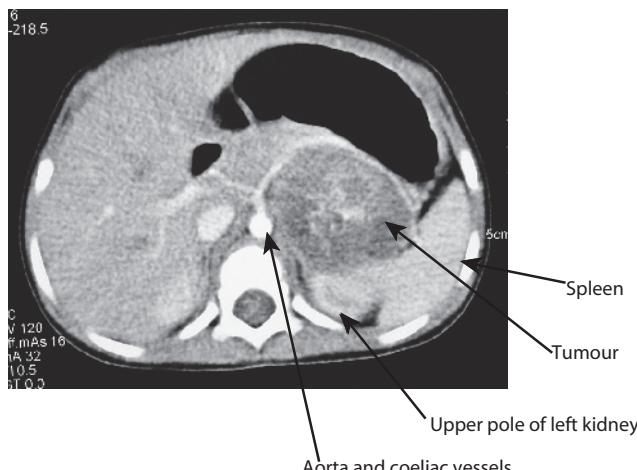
Transverse MRI image showing a large left-sided primary neuroblastoma arising from the adrenal region and distorting coeliac and mesenteric blood vessels.
